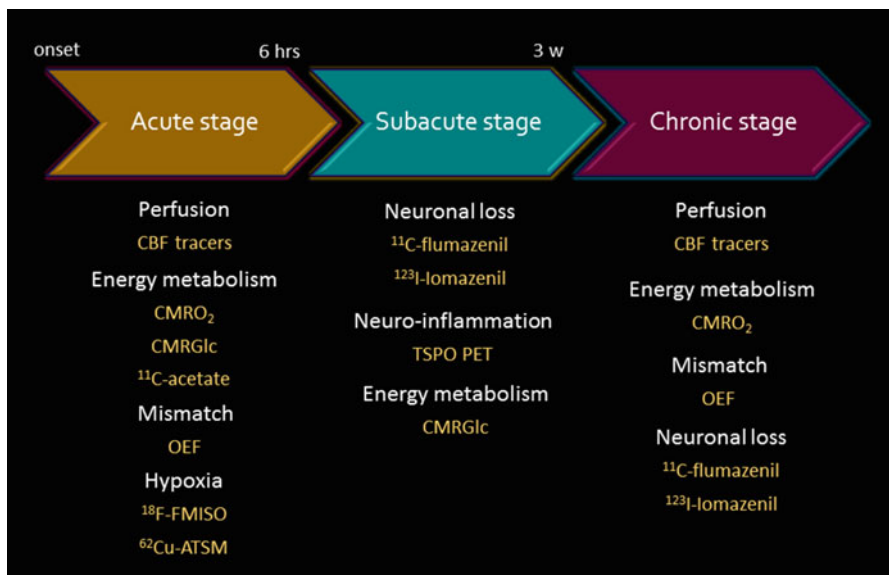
Time course of infarct evolution and related PET/SPECT imaging
